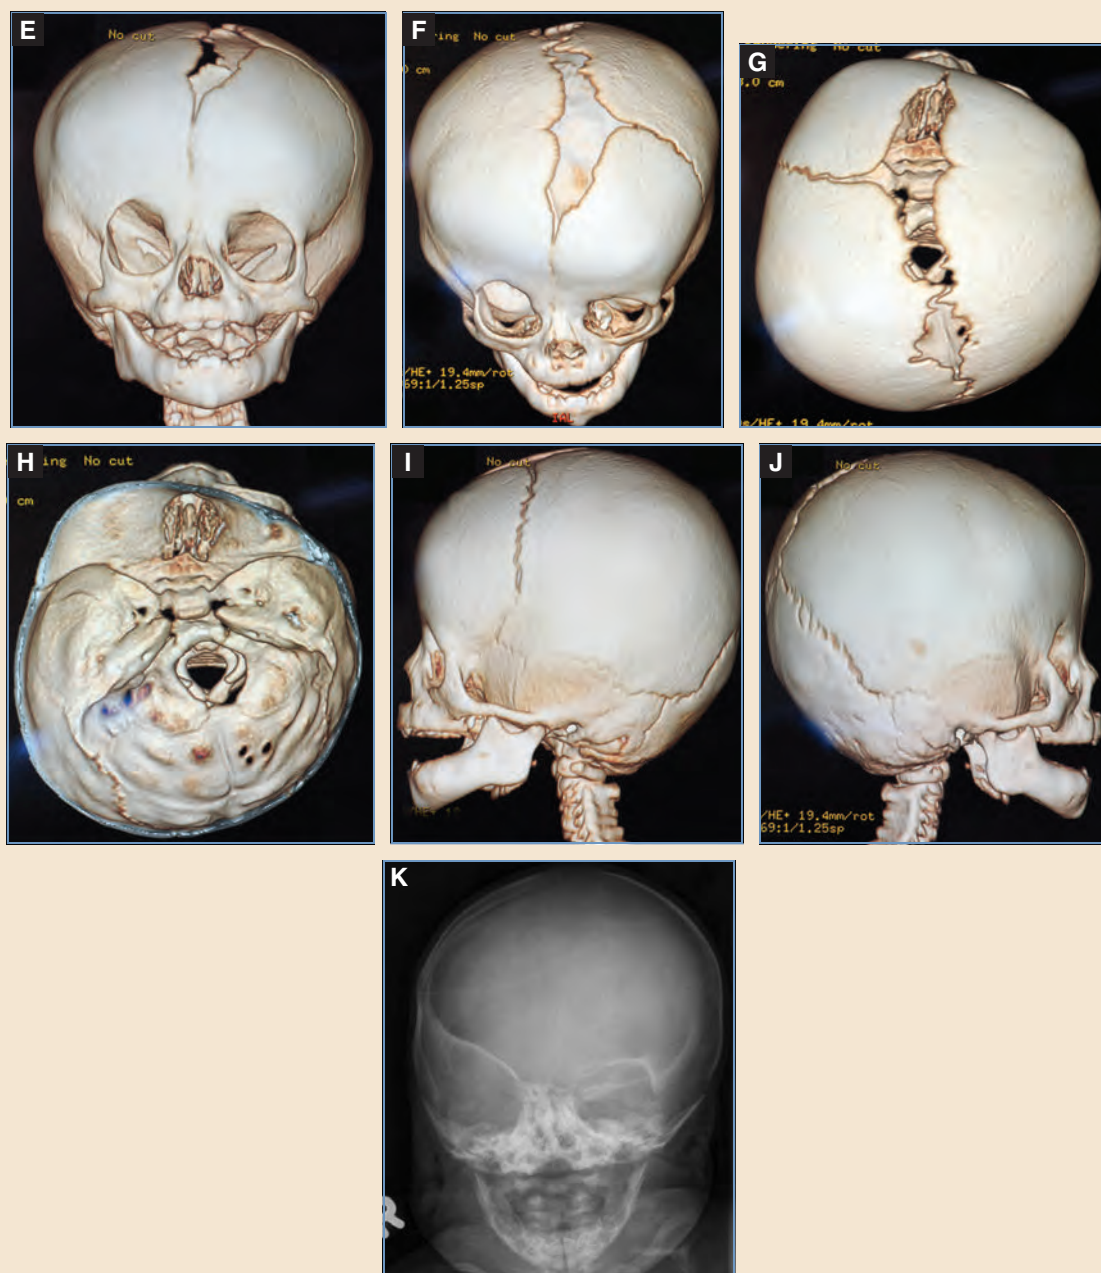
cont'd E-J, CT images show posterior angulation of the lateral orbital wall on the side of the fused suture and significant cranial base asymmetry. K, A plain radiograph demonstrates vertical orientation of the sphenoid wing, known as a *harlequin-eye sign*, on the side of the synostosed coronal suture.
